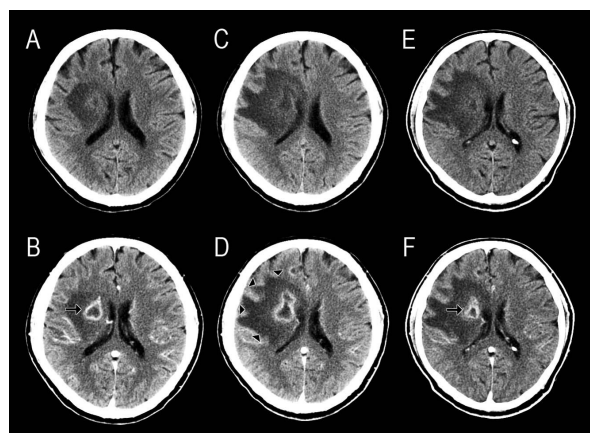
Serial brain computed tomography (CT) scans with (B, D, F) and without (A, C, E) contrast enhancement show the evolution of the brain abscess. On admission, a ring-enhanced lesion (arrow) with perifocal edema was found in the right corona radiata (A, B). Follow-up brain CT images (C, D) three weeks later revealed expansion of perifocal edema (arrowheads). Five weeks after admission, the brain abscess (arrow) had decreased in size (E, F).
